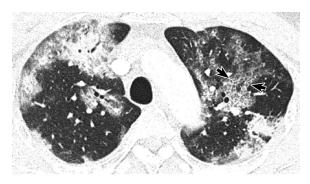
Crazy-paving pattern in the left upper lobe in a man with COVID-19. Axial CT image obtained 11 days after symptom onset shows intralobular lines within GGOs (arrows), which in combination with interlobular septal thickening create a cobblestone pattern characteristic of crazy paving.
